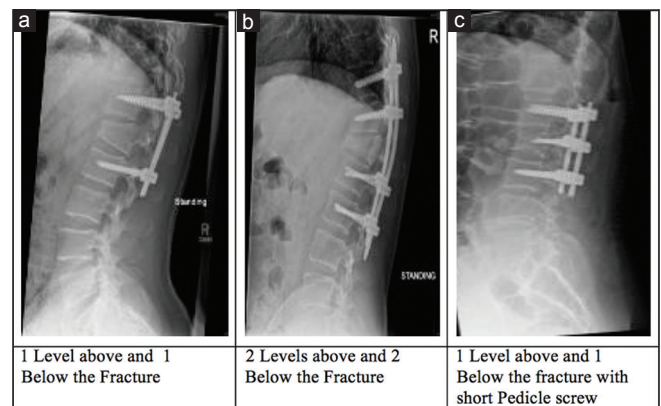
Examples of post-operative X-rays at 6 months. Source: Royal Preston Hospital, Department of Neurosurgery
